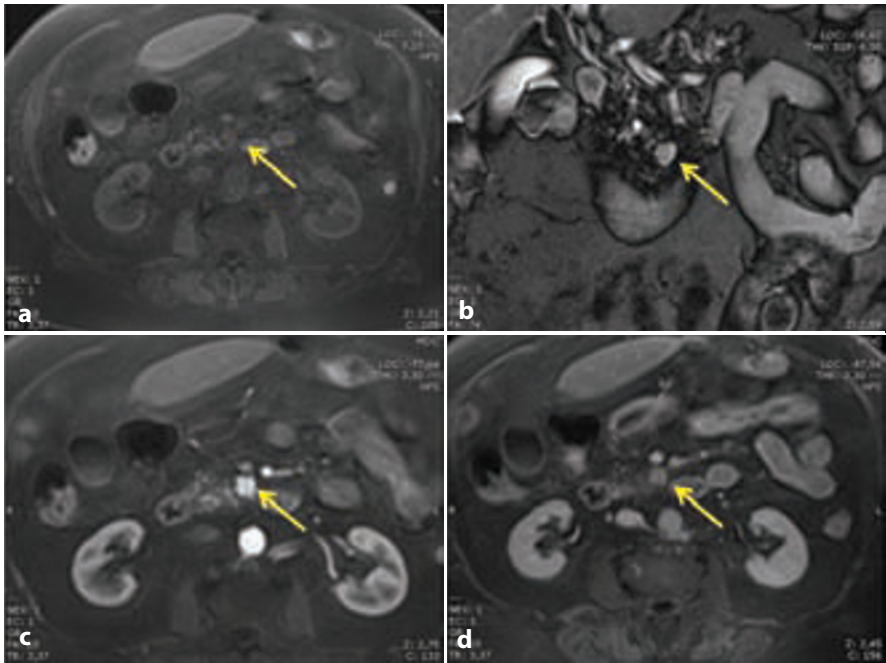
Typical MRI findings of insulinoma. The on baseline unenhanced scan shows the lesion (*arrow*) as hypointense on the fat-saturated, T1-weighted, axial image (a) and hyperintense on the coronal T2-weighted image (b). During the contrast-enhanced study, the lesion (*arrow*) shows the typical hypervascularity on axial images obtained during the arterial pancreatic phase (c) and subsequent washout during late venous phase (d)
